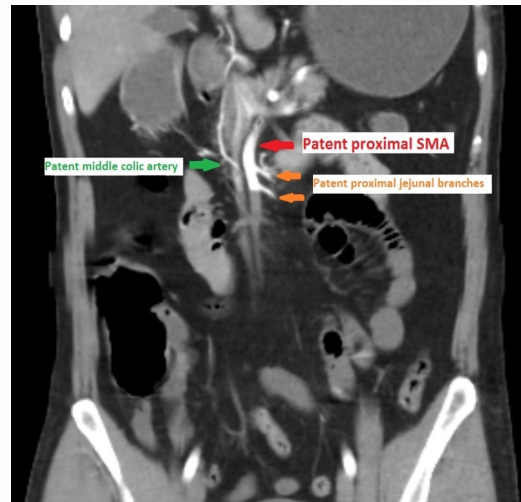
Coronal CT view showing arterial occlusive mesenteric ischemia. Source: Radiopaedia.
